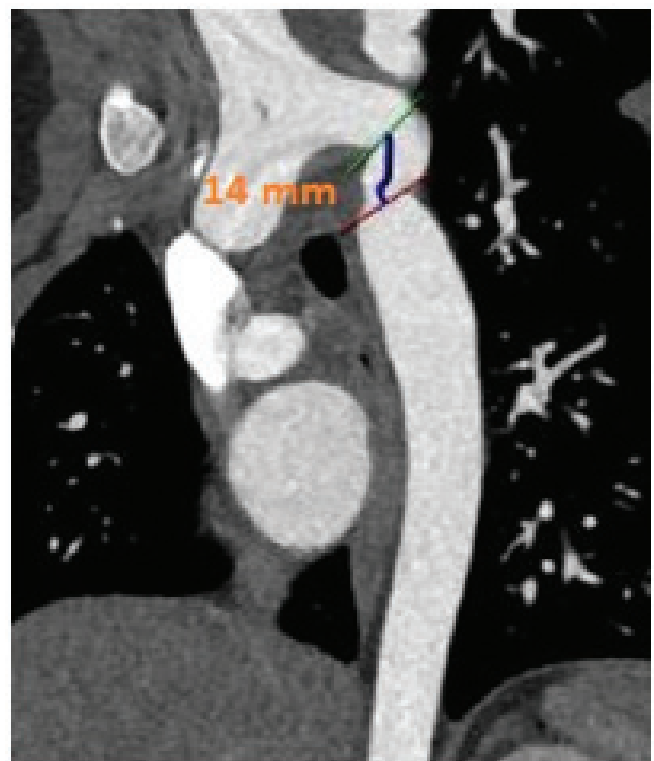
CT Aortogram – 2-dimensional (2D) image showing the length of the tortuous segment
